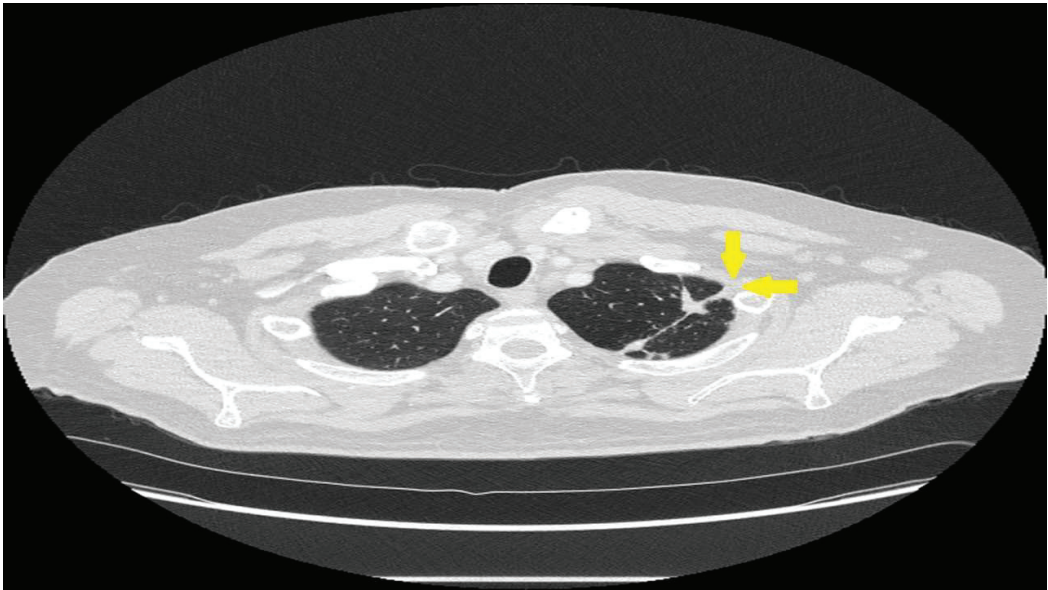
Although most chest pain in pulmonary sarcoidosis is unrelated to specific lung lesions, it may be related to pleural lesions on occasion. The CT scan shows an intraparenchymal pulmonary sarcoidosis lesion that extends to the pleura (arrows). This was the exact location of the patient’s pleuritic chest pain. The pain responded to anti-sarcoidosis therapy.
